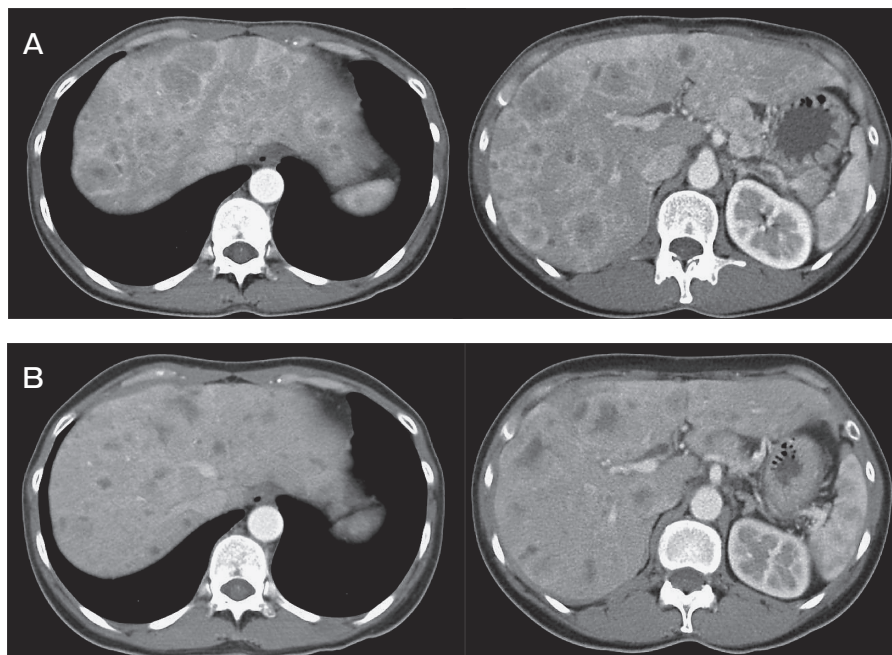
Contrast CT scans before TAE (A) after TAE (B). Reduction of the tumor volume and necrosis was observed in most of the multiple liver metastatic nodules.
